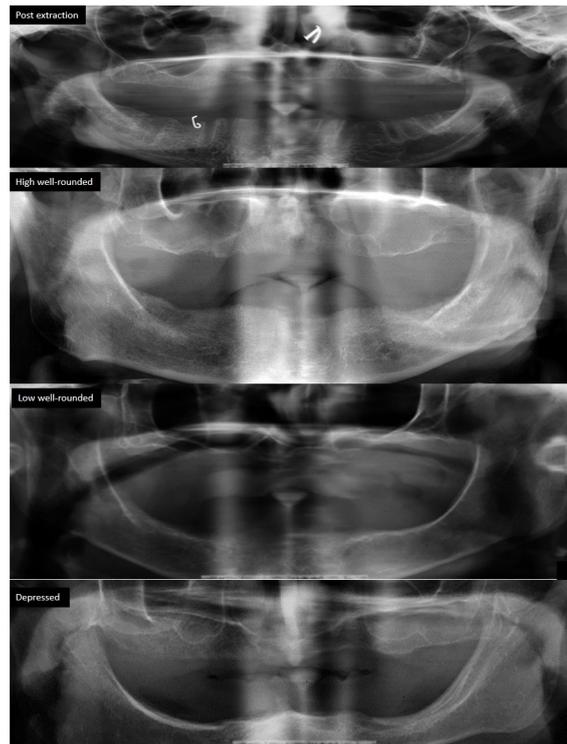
Panoramic radiographs depicting types of residual ridge patterns.
